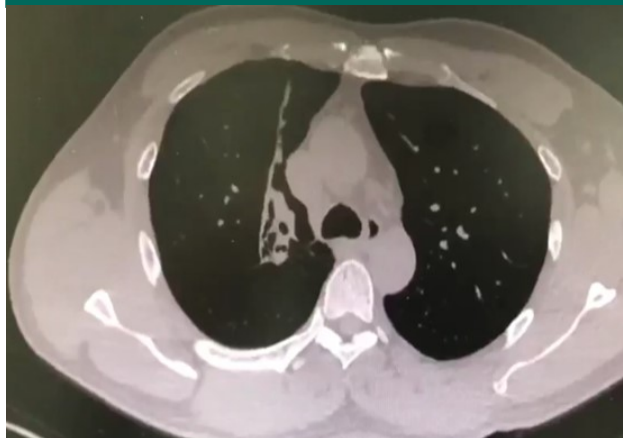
CT scan of the chest showing the nodule in the right upper lobe bronchus
